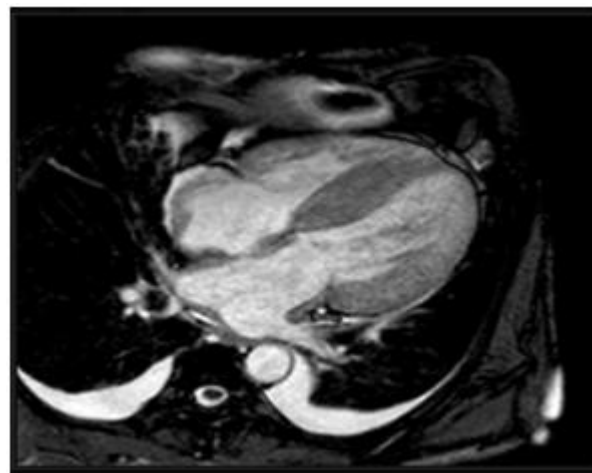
Cardiac MRI of a patient with amyloidosis
